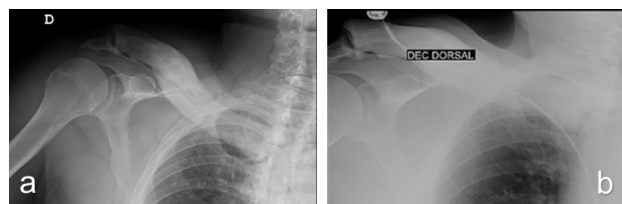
On conventional radiograph, a diffuse enlarged right clavicle is seen, with the loss of the medullary cavity, thickening of the cortex and a predominantly sclerotic pattern (image a). Note the stability after one year (image b), favouring the diagnosis of Paget's disease.
